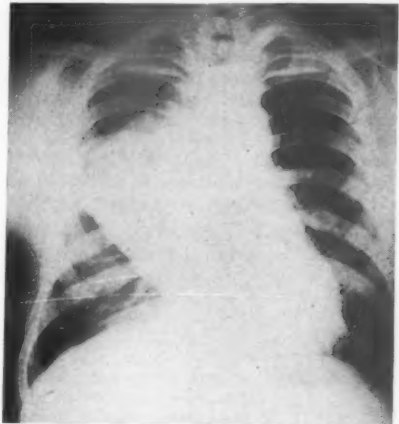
Case 2. Postero-anterior X-ray. Teratoma. Note angular outline.
